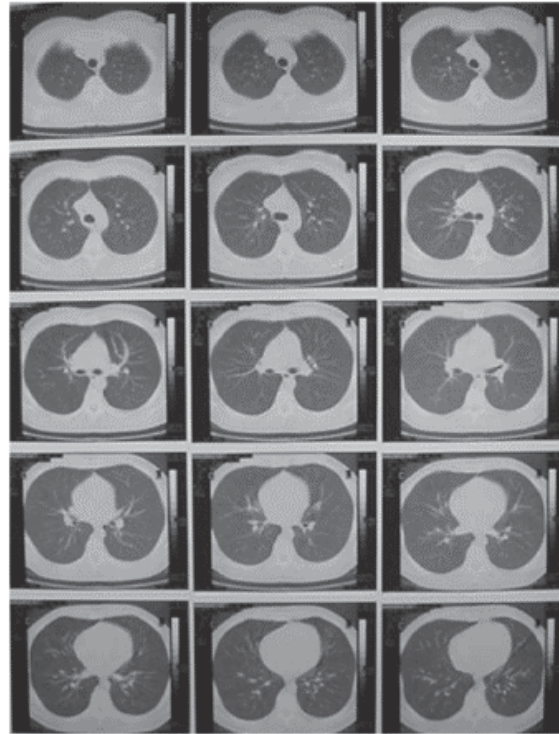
Chest computed tomography seven days after discharge from the intensive care unit showing normality of the lung parenchyma
